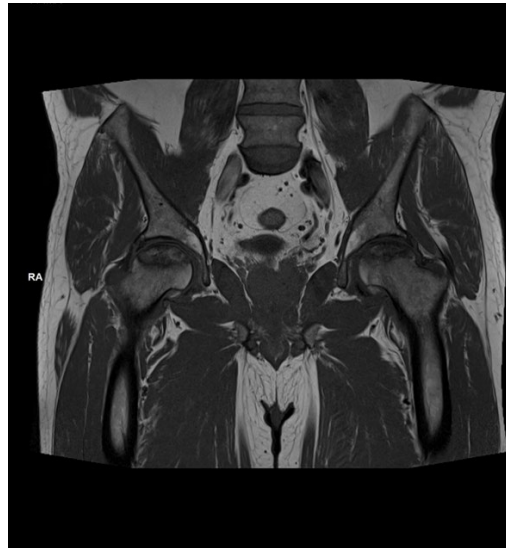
MRI of the hip joints confirmed bilateral AVN
